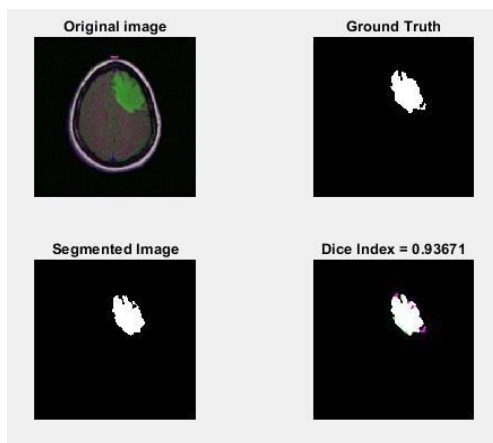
Segmented result for LGG MRI 3
